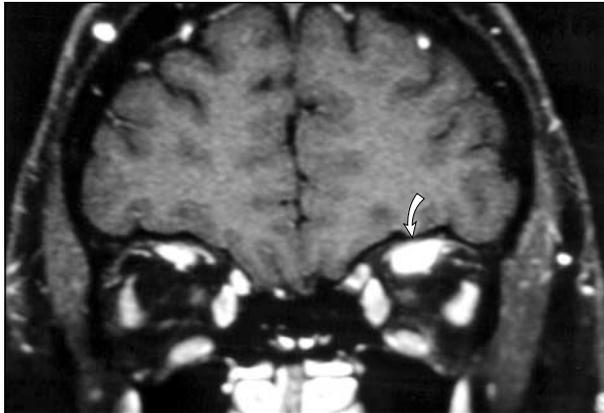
Postgadolinium coronal magnetic resonance imaging demonstrating a thickened and enhancing left superior rectus muscle (arrow) when compared with the right.
